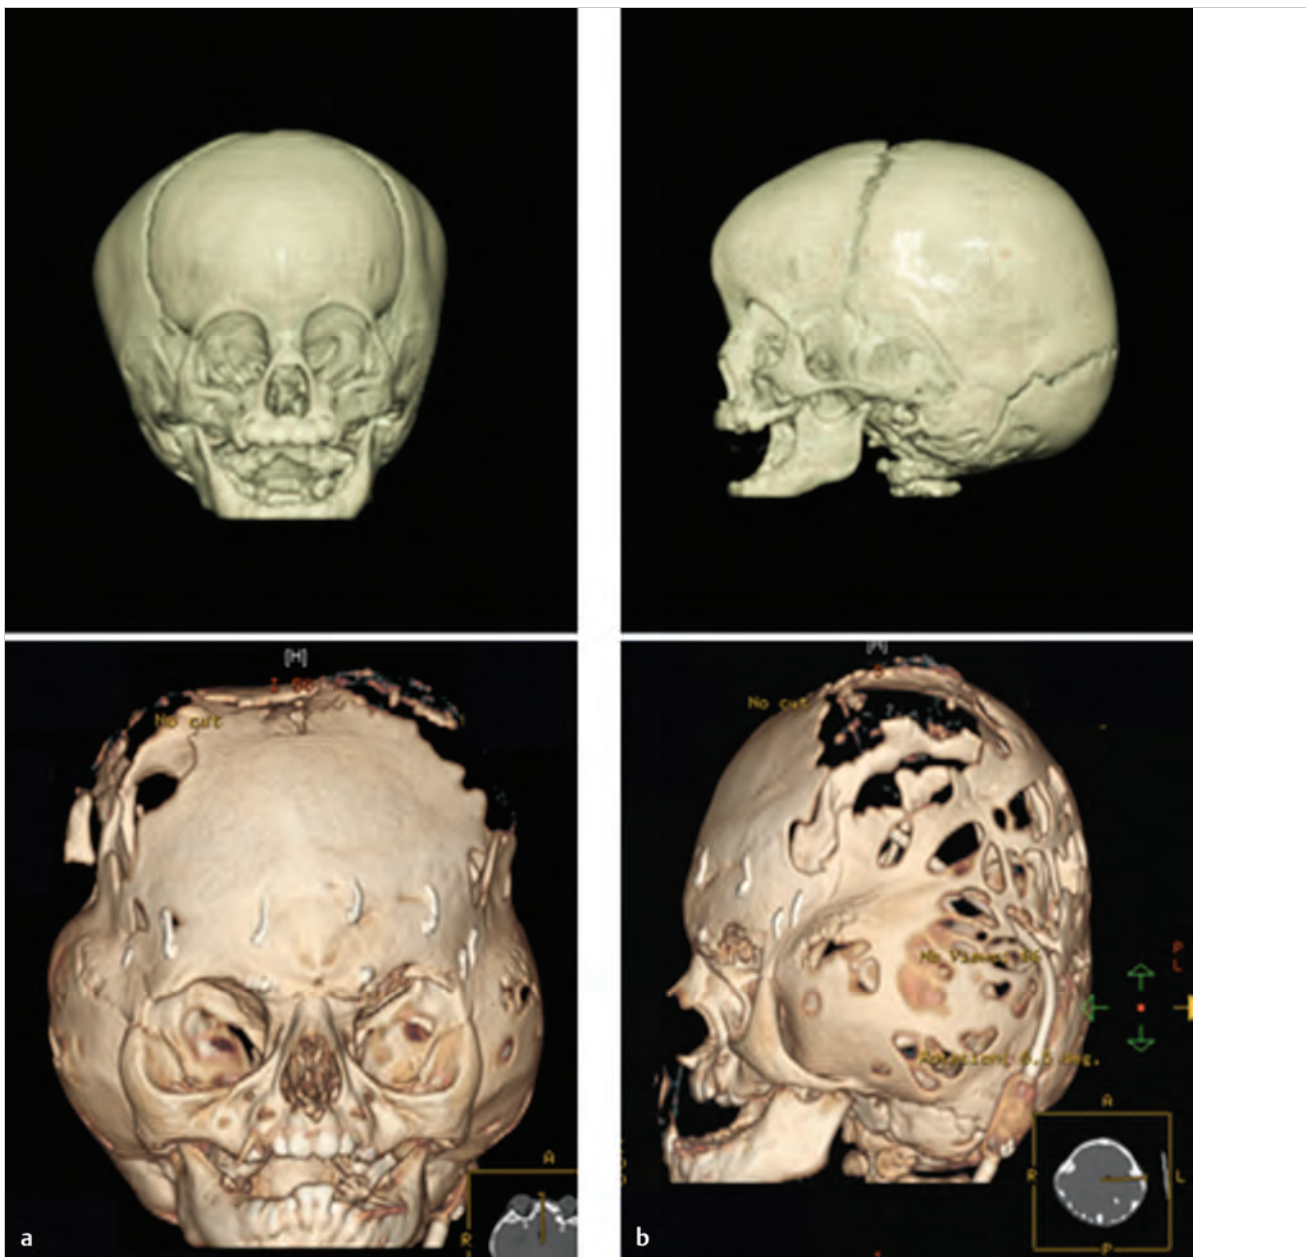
Three-dimensional CT scan demonstrates the bilateral coronal synostosis and midface retrusion common in many syndromic craniosynostosis cases, as compared to nonsyndromic, single-suture synostosis. (a) Metopic synostosis with patent coronal sutures and no midface retrusion. (b) Apert's syndrome with bilateral craniosynostosis and midface retrusion.
